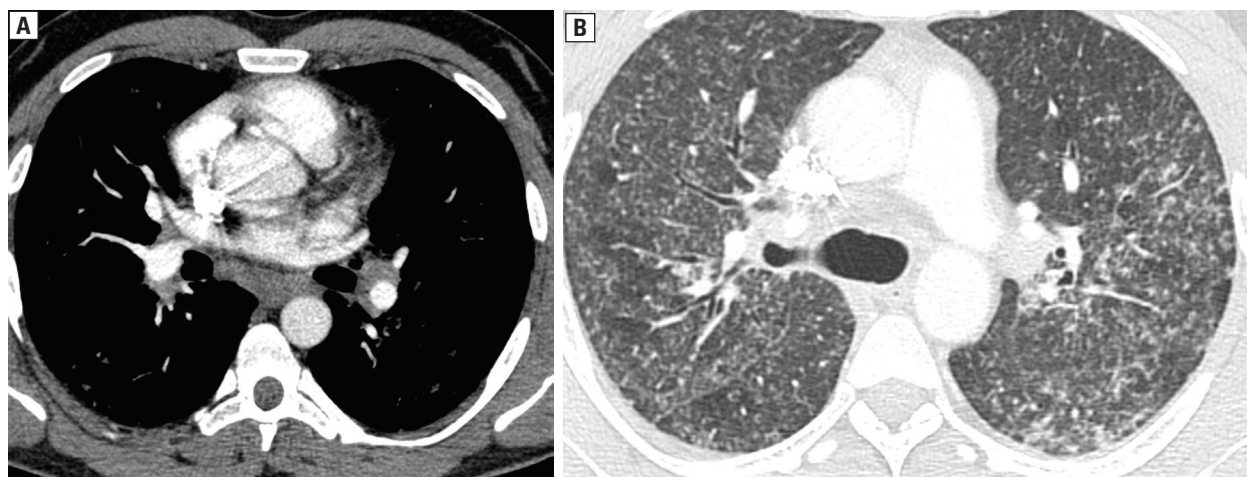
Contrast enhanced computed tomography (CT) scan, mediastinal window, at the level of hila, depicts hilar and subcarinal lymph nodes enlargement; B. High-resolution CT (HRCT) scan at the level of trachea demonstrates multiple small nodules in upper lobes in peribronchiolar location, mainly subpleural and perifissural
